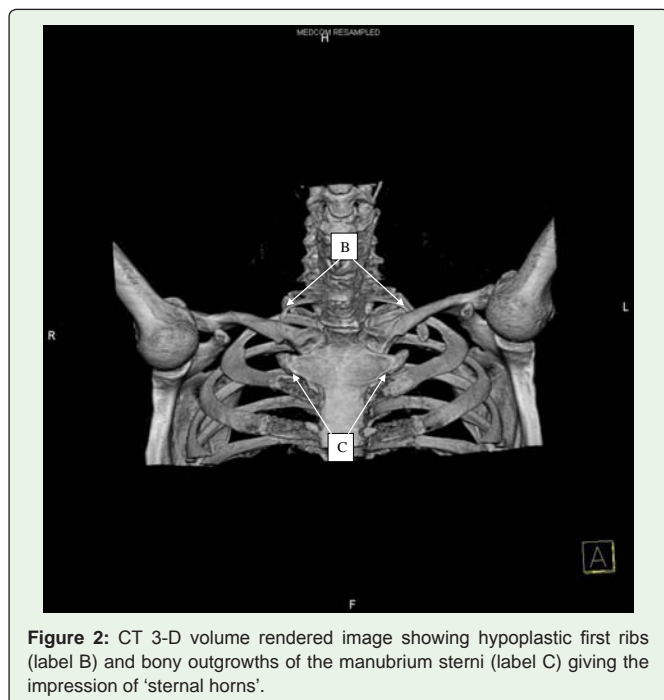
CT 3-D volume rendered image showing hypoplastic first ribs (label B) and bony outgrowths of the manubrium sterni (label C) giving the impression of 'sternal horns'.
